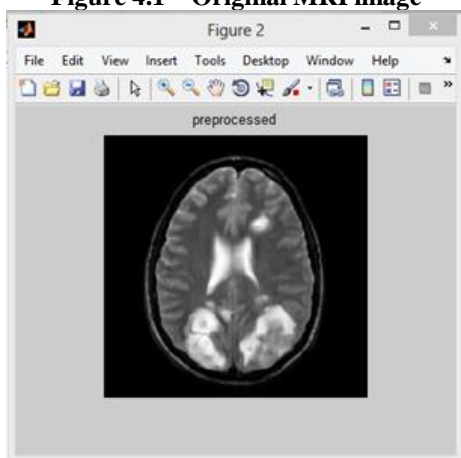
Preprocessed MRI image
